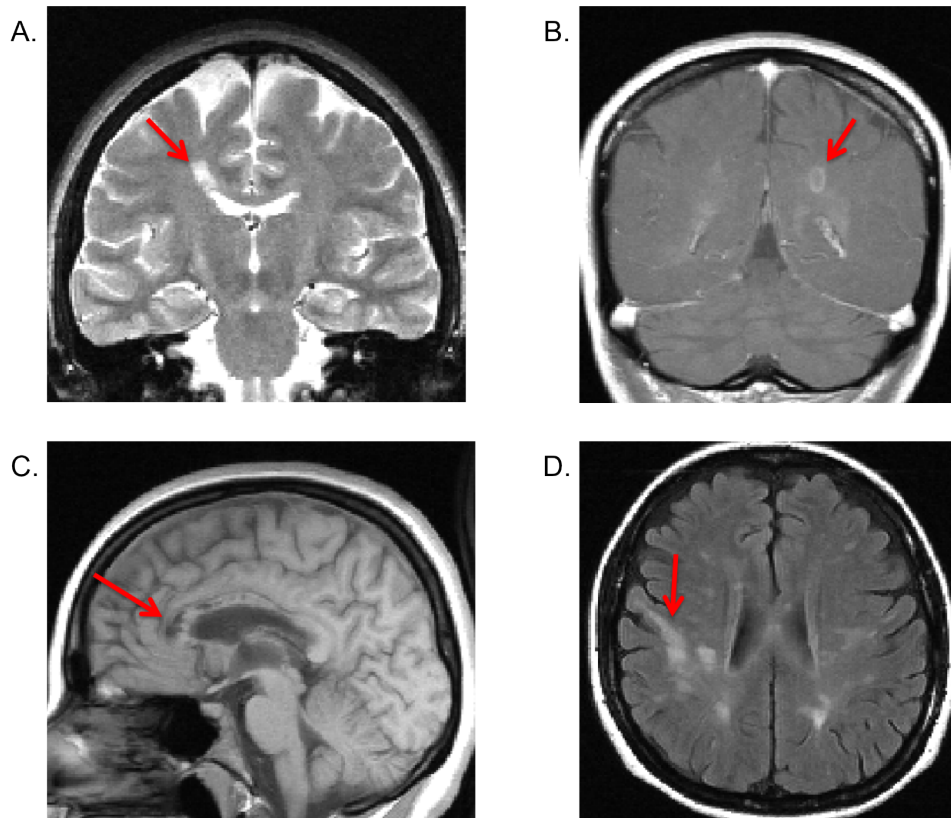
A.) T2 spin echo weighted image showing a typical hyperintense “Dawson finger” starting from the ventricle edge and extending deeper into the white matter. B.) T1 weighted image with contrast medium (Gadolinium) showing a ring enhancement surrounding an acute demyelinating lesion. C.) T1 weighed image showing chronic hypointense demyelinated lesions in the corpus callosum, an important sign of axonal degeneration. D.) T2 FLAIR weighted image with hyperintense lesions in the deep white matter that extent towards the subcortical white matter within the gyri.
